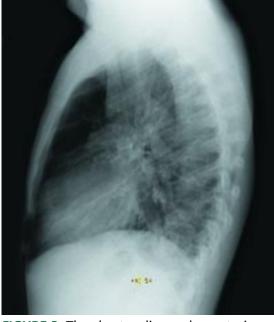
The chest radiograph, posterioranterior view (top) and lateral view (bottom) both show subtle basilar infiltrates.
